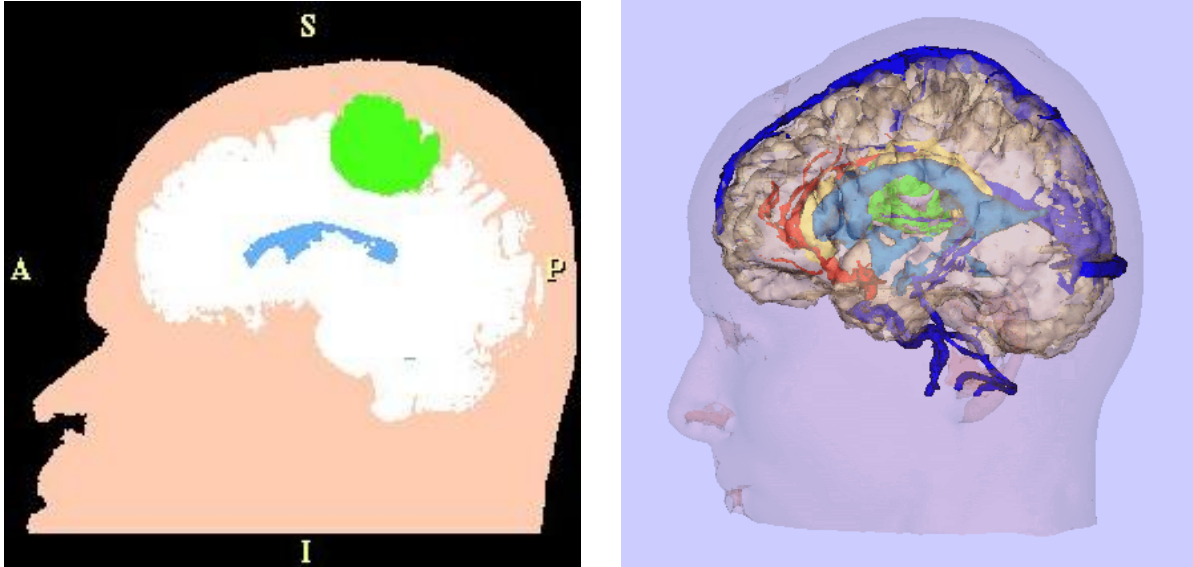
Left: a segmented MRI slice showing skin in pink, brain tissue in white, ventricles in blue and tumor in green. Right: a three-dimensional rendering of segmented skin surface, brain tissue, major blood vessels, and tumor from a diagnostic MRI scan.
